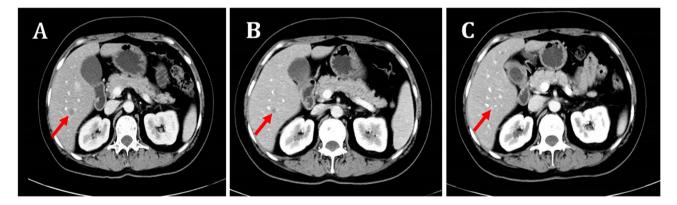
Liver CT results showing the patient response after treatment with utidelone combined with anlotinib: CT scans (A) at baseline, (B) after two cycles of treatment and (C) after four cycles of treatment. Metastatic size reduction was as follows: (A) 12 mm, (B) 8 mm and (C) 4 mm. The red arrows indicate the metastasis. CT, computed tomography.
